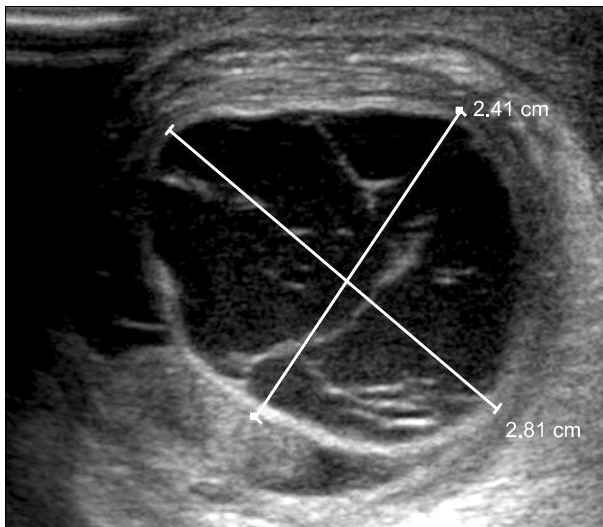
Ultrasonography revealed a normal right testis with septated paratesticular cystic mass.
